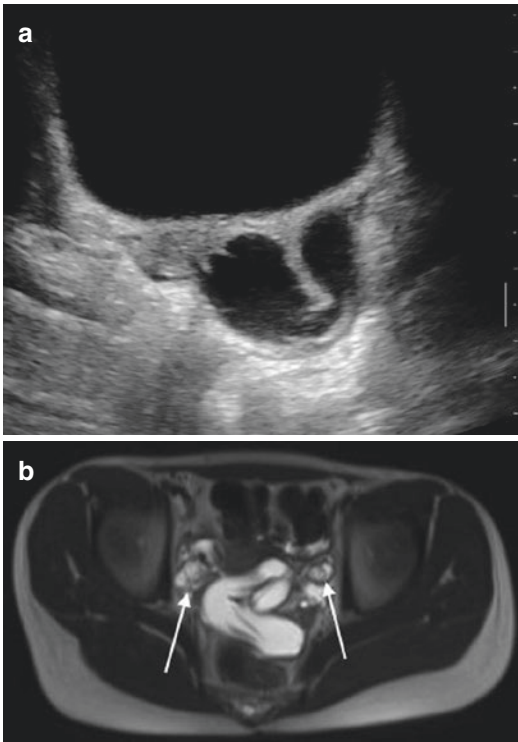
Isolated left fallopian tube torsion in a 12 year-old girl, confirmed at laparoscopy. (a) US Axial view: Isolated tubal dilatation with presence of plicae tubariae and thickening of tubal walls. (b) MR imaging: Axial T2-Weighted sequence. Two normal ovaries (*two arrows*) with isolated hydrosalpinx
